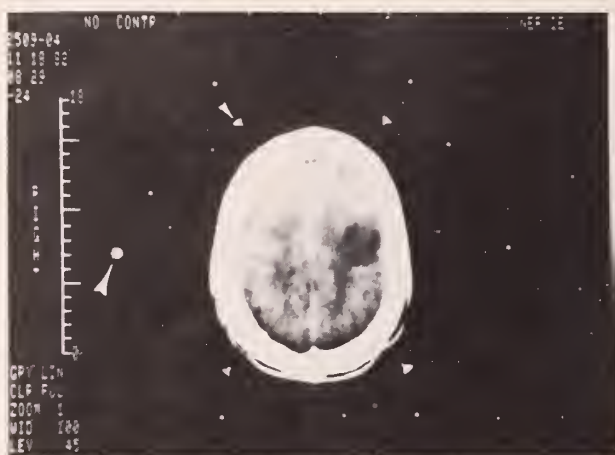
CT scan shows lucent tumor in left frontal lobe. Large arrow (pointing upwards) indicates position of large vertical rod of localizing ring present on patient's right. Smaller arrow (pointing downwards) indicates one of 4 vertical posts that fixate the stereotaxic ring to the skull.
